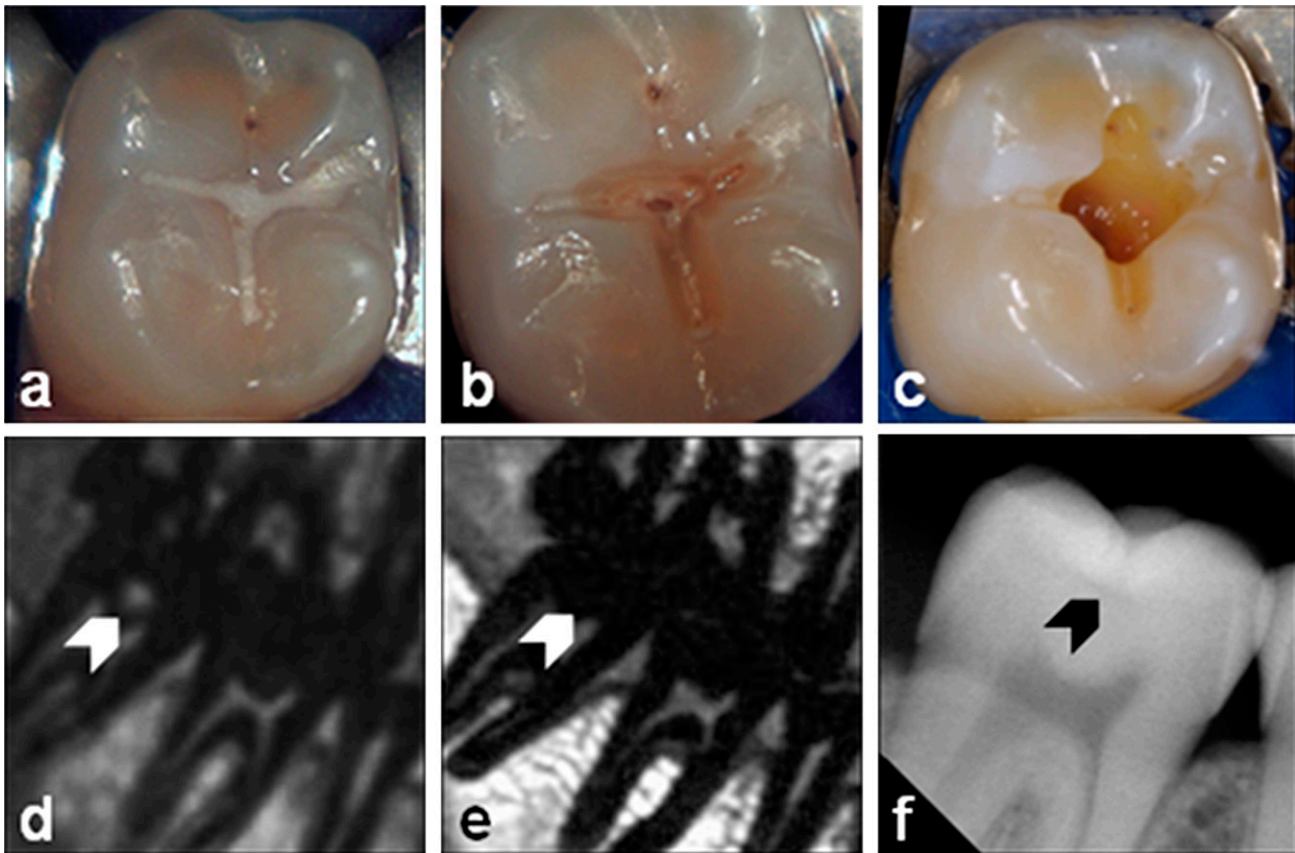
Occlusal (hidden) caries (CII): intraoral pictures of dental treatment (a) prior to the treatment, (b) after fissure sealant removal and (c) after excavation, and the respective three-dimensional ultrashort echo time (d) multislice turbo spin-echo (e) and X-ray (f) images. The white arrows in the MR images and the black arrow in the X-ray image indicate the lesion
